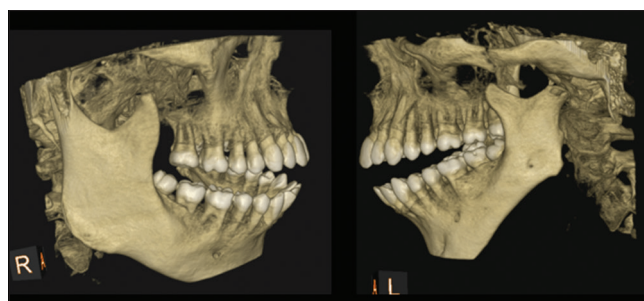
Three-dimensional reconstructed cone-beam computed tomography view showing hypoplasia of the left condyle in comparison to the right
